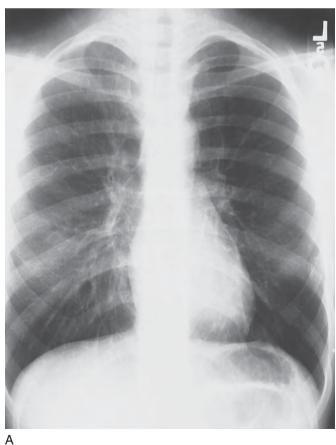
Juvenile rheumatoid arthritis patient with a hyperlucent left lung owing to a paucity of pulmonary vasculature (A). Perfusion scintigraph shows marked decreased perfusion of the left lung and patchy perfusion of both lungs (B). This finding is consistent with bronchiolitis obliterans, although additional considerations include vasculitis and multiple pulmonary emboli.
